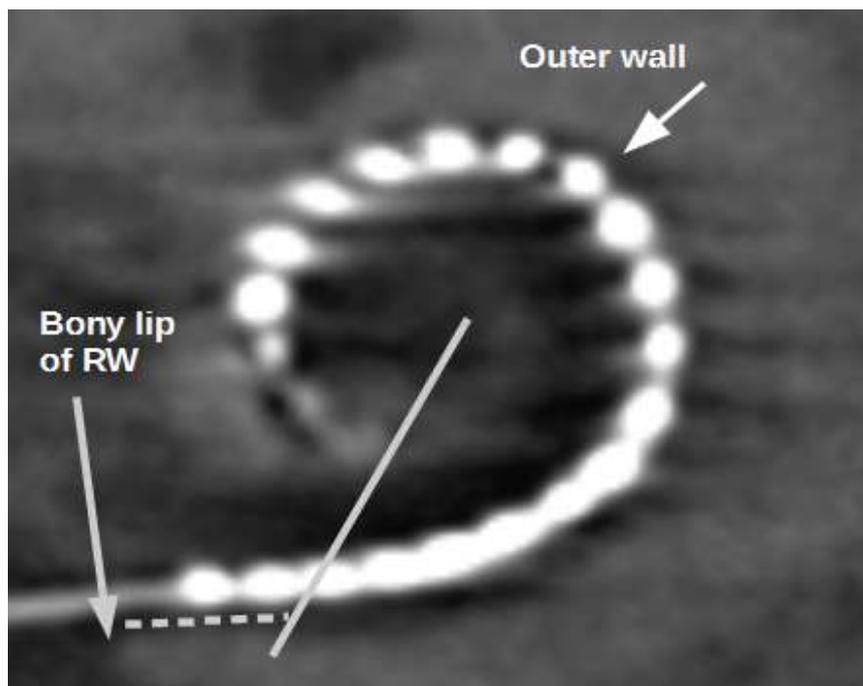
Cone-beam computed tomography (CBCT) image of implanted electrode array (Slim Straight Electrode) showing four landmarks for measurement of cochlear length: (i) bony lip of round window (RW), (ii) outer wall, (iii) modiulus, and (iv) most apical electrode (#22). These are used to calculate the number of electrodes inserted at 360° (solid line) and length between this point and the RW bony lip (dashed line). See text for details.
